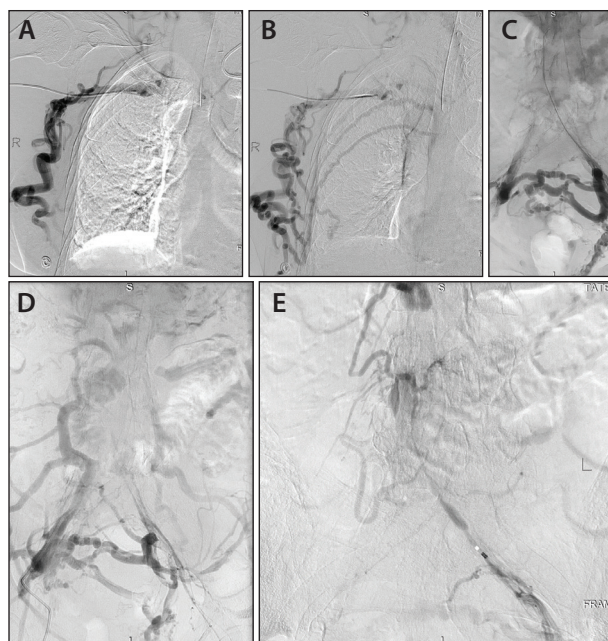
Venograms demonstrating CVO involving the SVC and IVC. Venogram obtained through ultrasound-guided puncture of the right brachial vein showing occlusion of the distal subclavian vein, innominate vein, and SVC venous outflow (A); later images from panel A showing marked cross-chest collateralization but no opacification of the SVC (B). Attempted recanalization of the left iliac venous occlusion (C); later images from panel C showing marked cross-pelvic collateralization, without opacification of the IVC but with filling of robust collaterals (D). The IVC is occluded but demonstrates one patent segment that does not connect directly with the RA (E).
